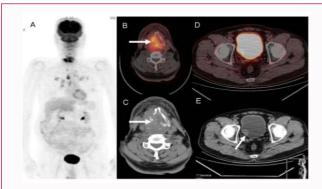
A case of laryngeal carcinoma. MIP image (A) shows increased uptake at the primary site with intrathoracic spread. The FDG avid invasive laryngeal mass is well seen on the PET/ CT and CT image (B,C). Additionally, an unsuspected bladder mass is seen on the CT image (E), which gets obscured on the PET/CT image by the physiological high uptake in the bladder (D).
